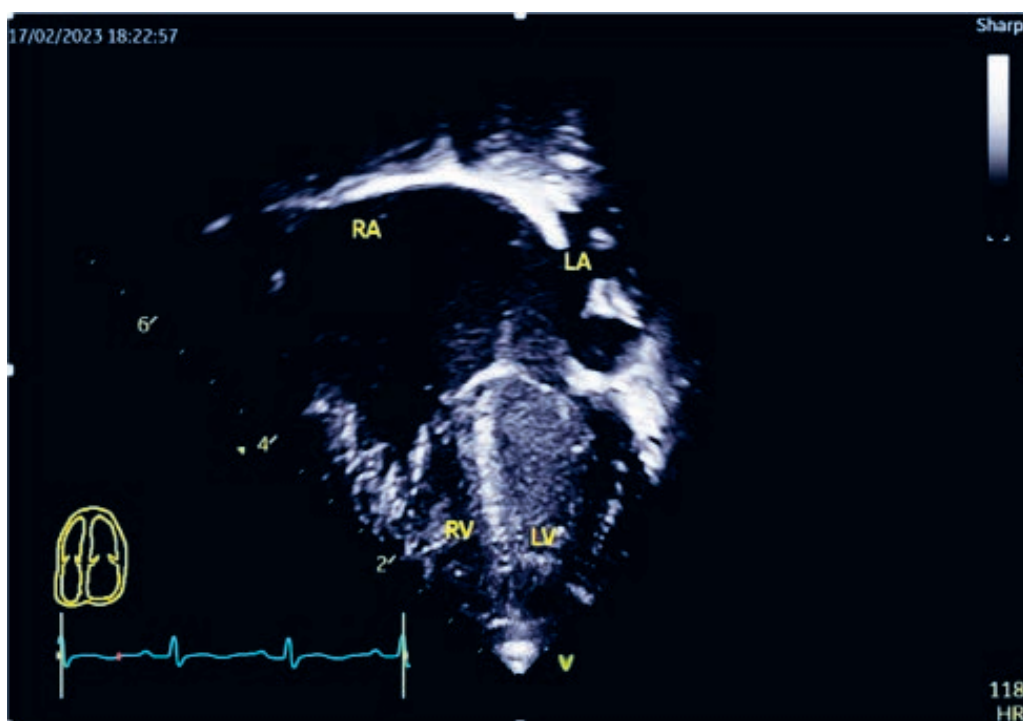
Apical 4 chamber view, showing the four chamber and right atrium enlargement
